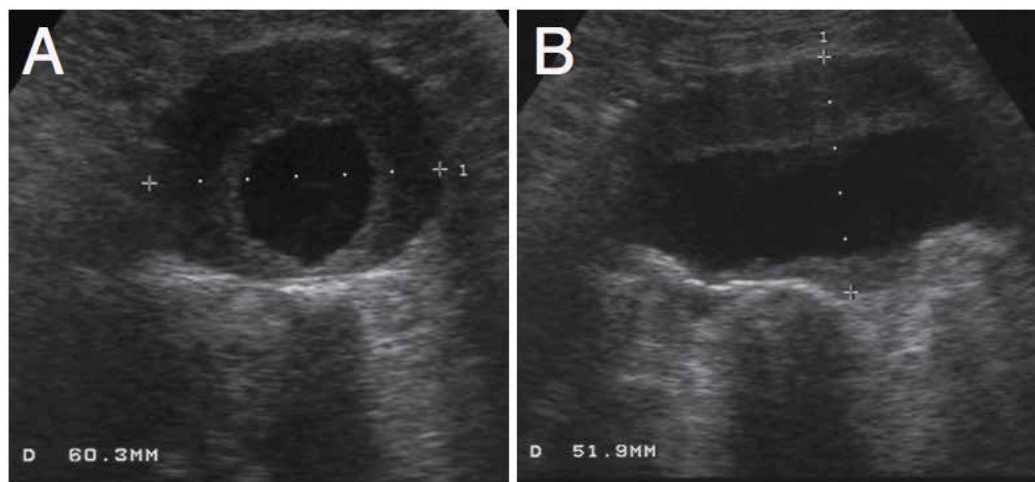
Ultrasound images of AAA. Cross-sectional (A) and longitudinal (B) views. Courtesy of Asbjørn Ødegård, St. Olav's Hospital, Trondheim, Norway.
